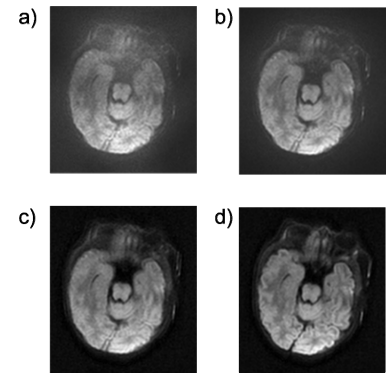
Isotropic DWI of Patient A. a) using GRAPPA weights from 1st T_2w volume and magnitude averaging. b) "optimal" GRAPPA weights, magnitude averaging. c) as b), but complex averaging. d) as c), after 3D realignment and bad volume rejection (displayed FOV cropped down to ~13 cm)
